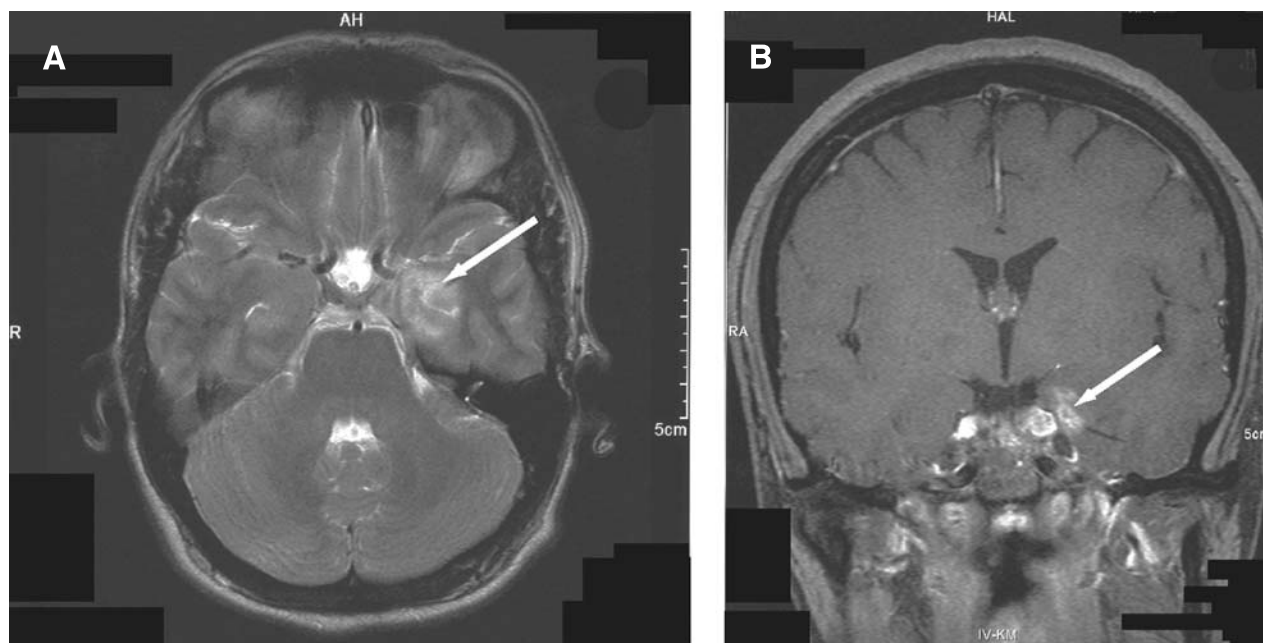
MR scans 19 months after gamma knife surgery. The T2-weighted image in 3A shows a diffuse signal hyperintensity in the left medial temporal lobe. This lesion enhances after gadolinium as displayed in 3B. The primary differential diagnosis was between low-grade glioma and radiation induced changes or necrosis
